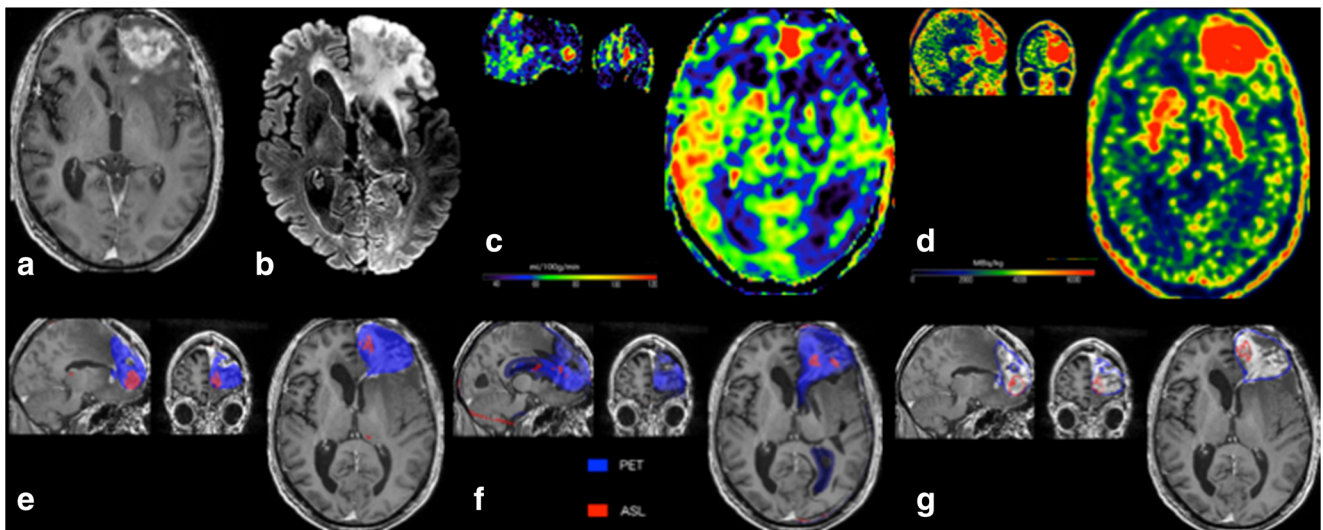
PET-MR of a 70-year-old male patient with a left-sided WHO IV glioblastoma without IDH mutation, treated by surgery and adjuvant radio-chemotherapy. Tumor progression was confirmed by the follow-up (true positive for ASL and PET). Upper row: a Enhancement at the initially treated frontal lesion site on a contrast-enhanced axial T1-w image. b Axial FLAIR-w image. c Hyper-perfusion with increased CBF on
